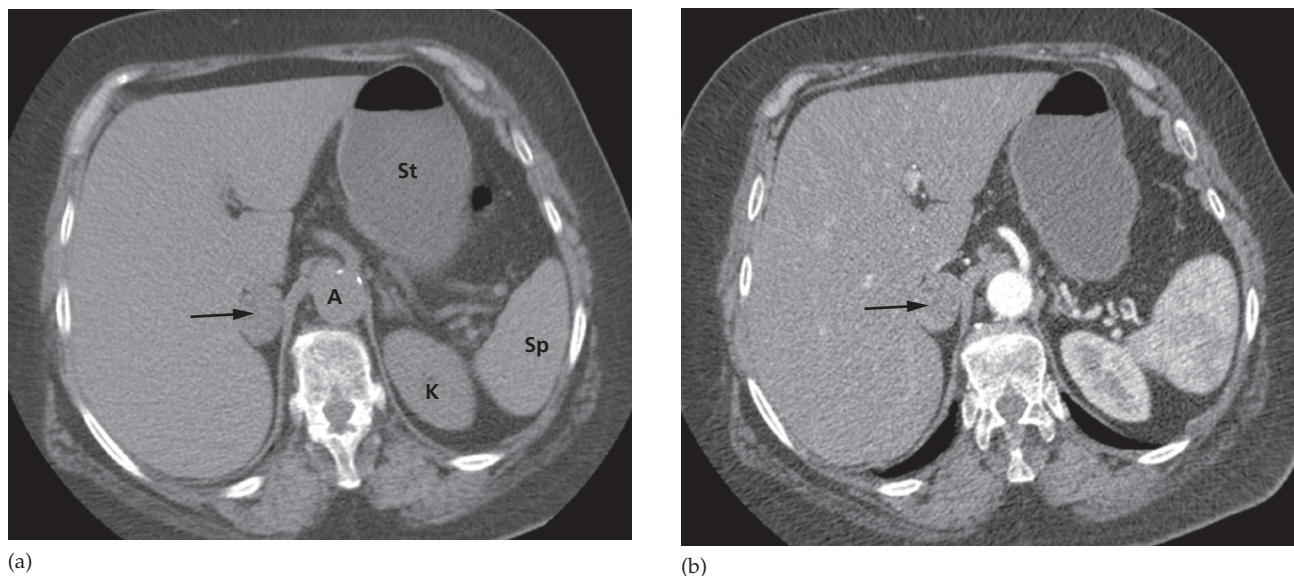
CT scan showing a right adrenal metastasis (arrow). (a) Non-contrast-enhanced study confirmed a density of 35 Hounsfield units. A, aorta; K, kidney; Sp, spleen; St, stomach. (b) Post contrast enhancement characteristics confirmed the presence of a non-adenomatous lesion.
